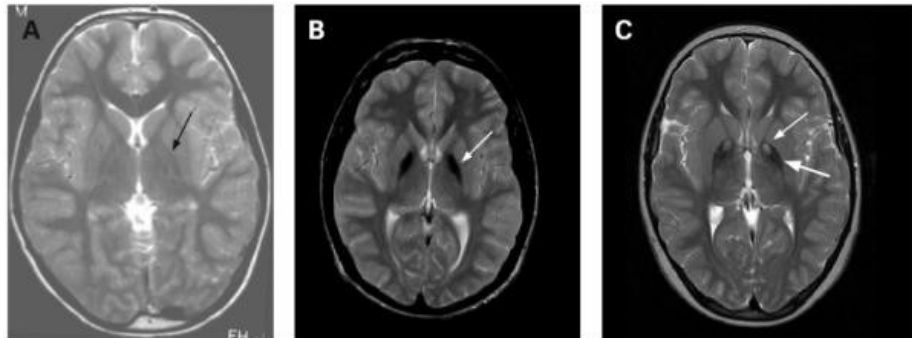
T2-weighted MRI profiles. It is shown a control (A), a NBIA patient (B) and a PKAN patient (C) with the classical ‘eye of the tiger’ sign. Hyperintense (white) signals indicative of tissue rarefaction are seen surrounded by areas of hypointensity (black areas) attribute to iron accumulation and visible also in B. (Gregory A 2009)
